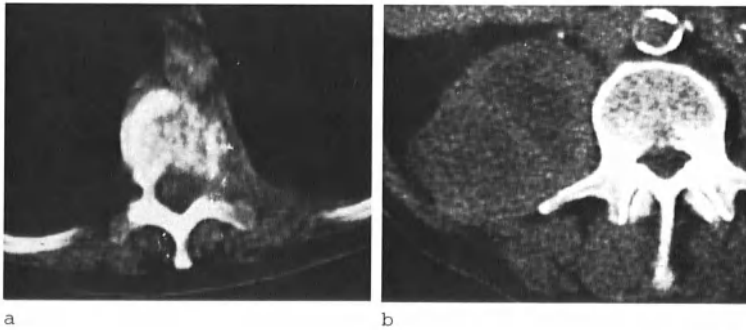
CT sections demonstrating: (a) Pedicular and vertebral bone erosion in paravertebral lymphoma. (b) Staphylococcal psoas abscess (note calcified aorta)
